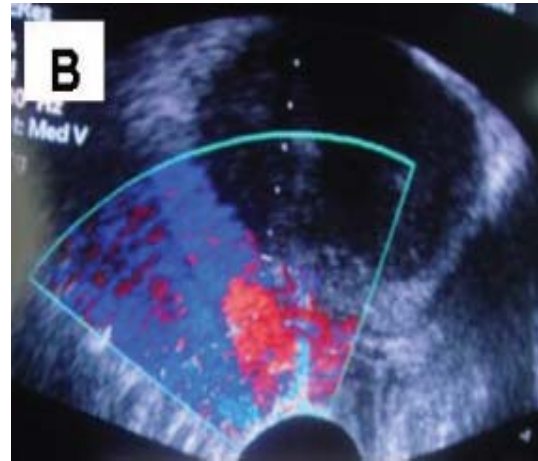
TRUS showing injection of lignocaine under Doppler guidance for basal periprostatic nerve block.
